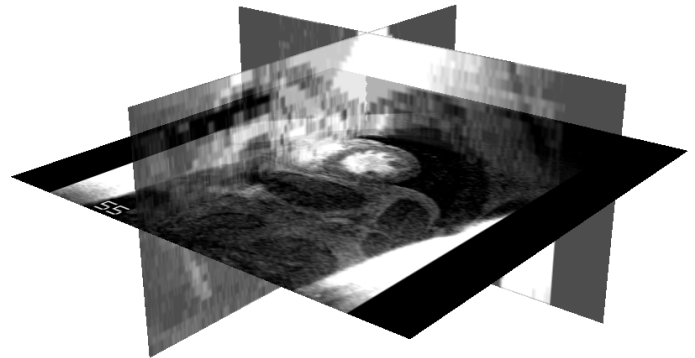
Cardiac MRI volume visualized using three orthogonal cutting planes (secondary planes are semi-transparent).
